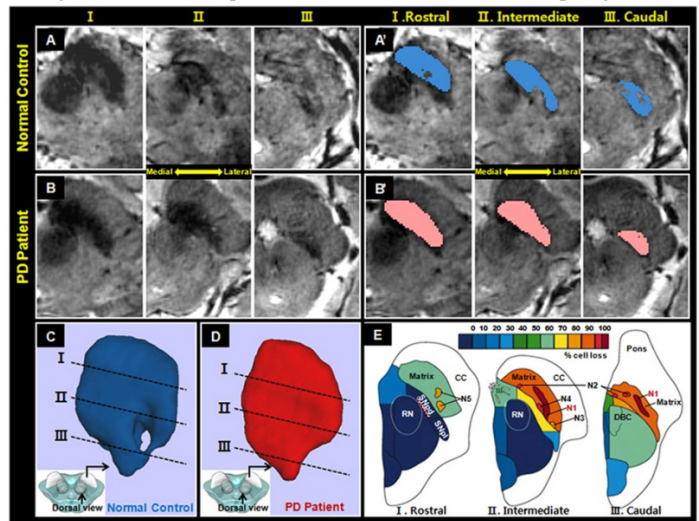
(A-B) 7T 3D T2*-weighted MR images. (A'-B') Traced image mask. (C-D) 3D reconstruction of the SN. (E) The regional and intranigral loss of dopamine-containing neurons of the SN in PD. (E) is reproduced from reference:[4]
